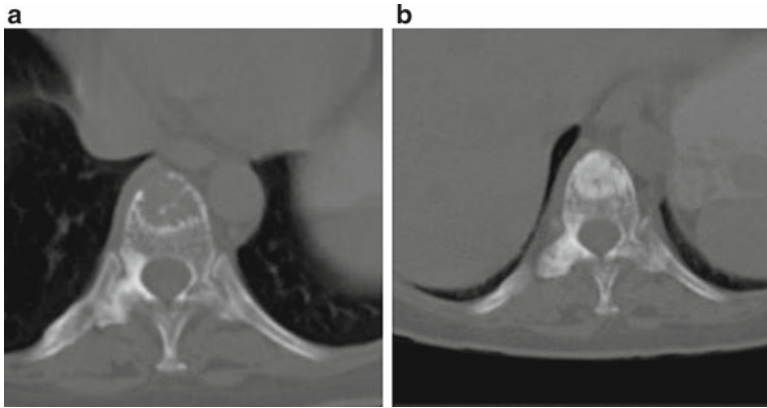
CT of thoracic spine presenting lytic metastasis from breast cancer (a). Osteosclerosis of the lesion after chemotherapy (b)
